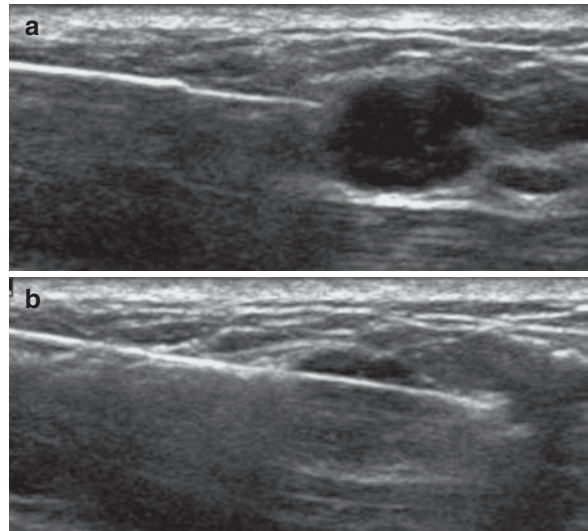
Ultrasound-guided core needle biopsy. (a) Pre-fire image shows the biopsy needle tip at the edge of the mass undergoing biopsy. (b) Post-fire image confirms that the biopsy needle is within the mass
